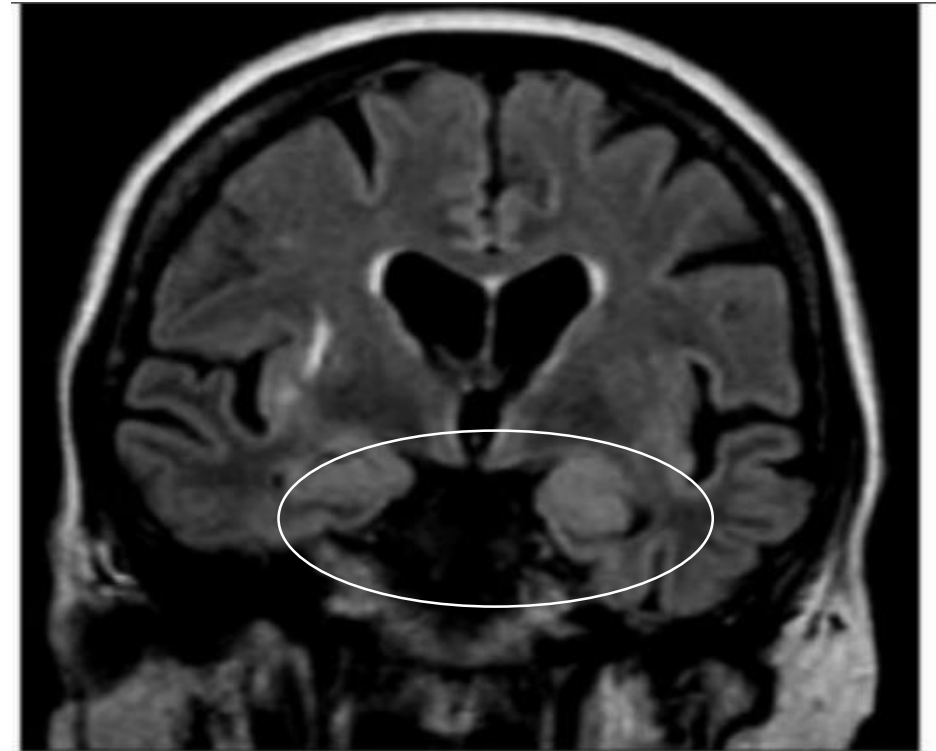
MRI FLAIR sequence coronal view showing bilateral high-signal changes in mesial temporal lobes and insular cortices.
